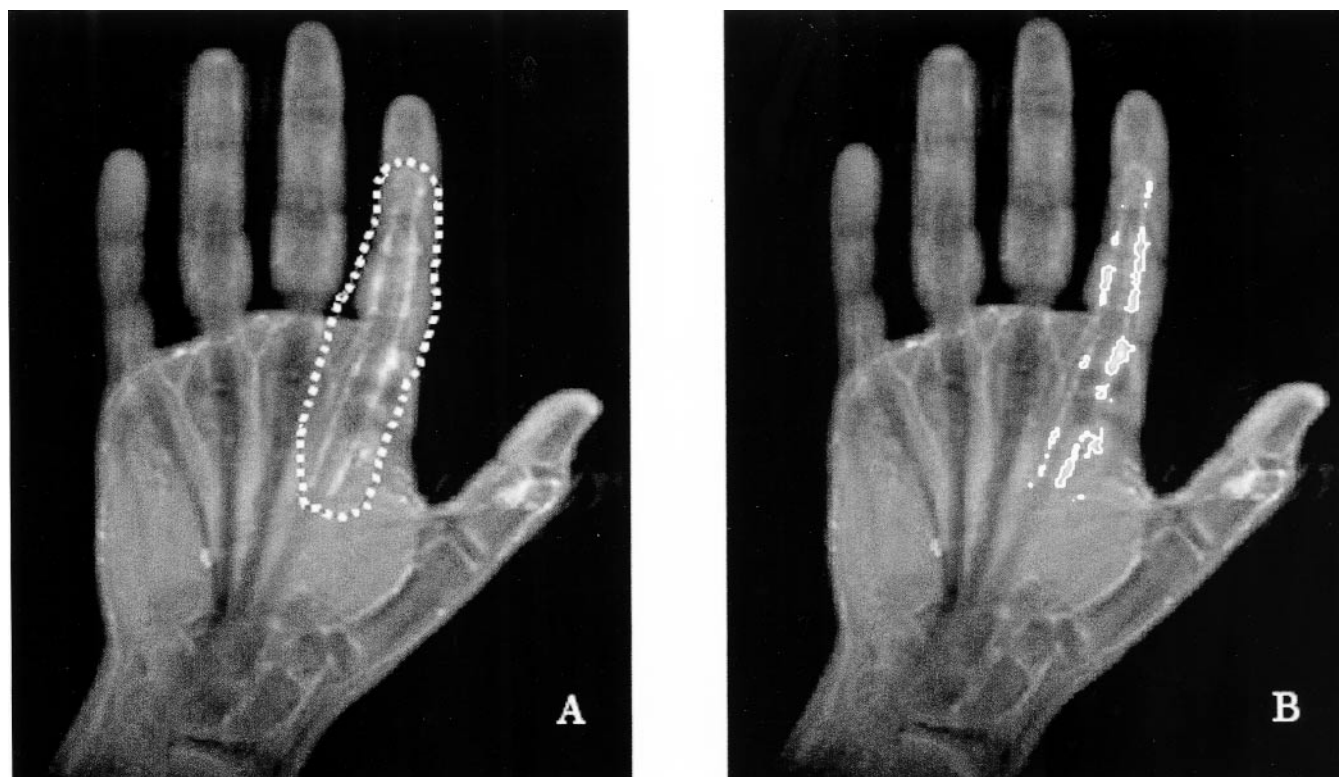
Coronal fat suppressed T1-weighted image of the hand following intravenous contrast administration shows synovial enhancement around the flexor tendon of the second digit and at the interphalangeal joint of the thumb (400/14 TR/TE, 4/1 slice thickness mm/gap thickness mm, 256 × 160 matrix, 18 cm FOV). (A) Operator-drawn region of interest around the enhancing synovium of the second flexor tendon. (B) Automated computer segmentation of the brightest pixels in the region of interest drawn around the second flexor tendon in A.
